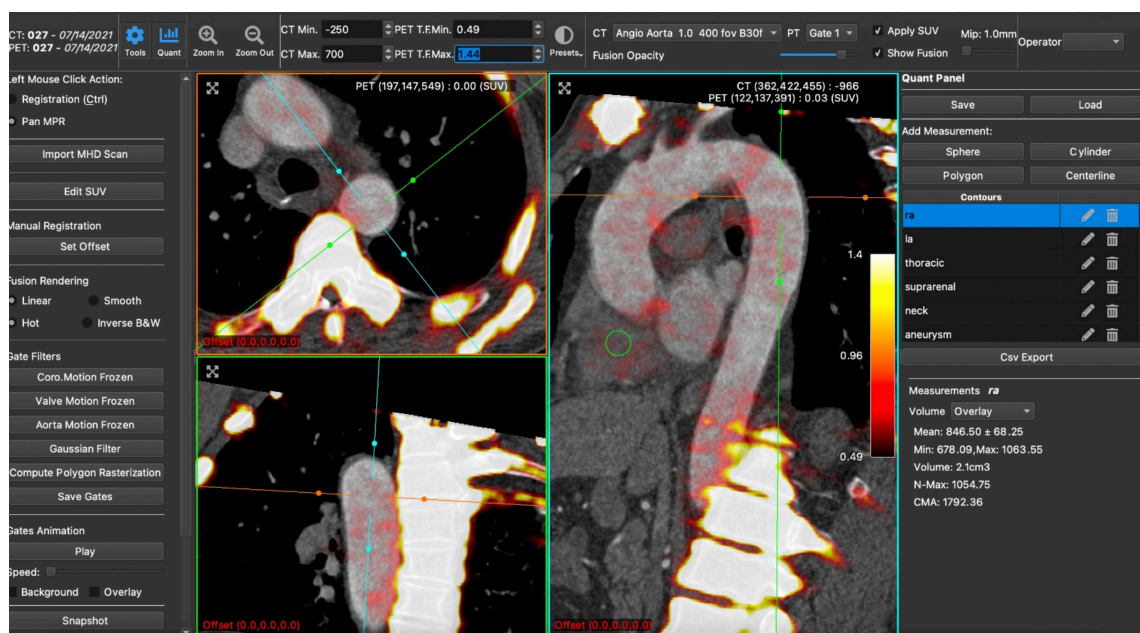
¹⁸F-Sodium fluoride positron emission tomography and computed tomography image analysis using FusionQuant. The images have been loaded and coregistered. A region of interest is drawn by the user (green) to obtain standardised uptake values.
